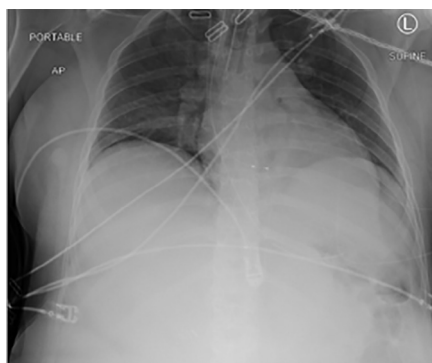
A chest radiograph with a temporary pacemaker wire and an endotracheal tube in the appropriate positions.
